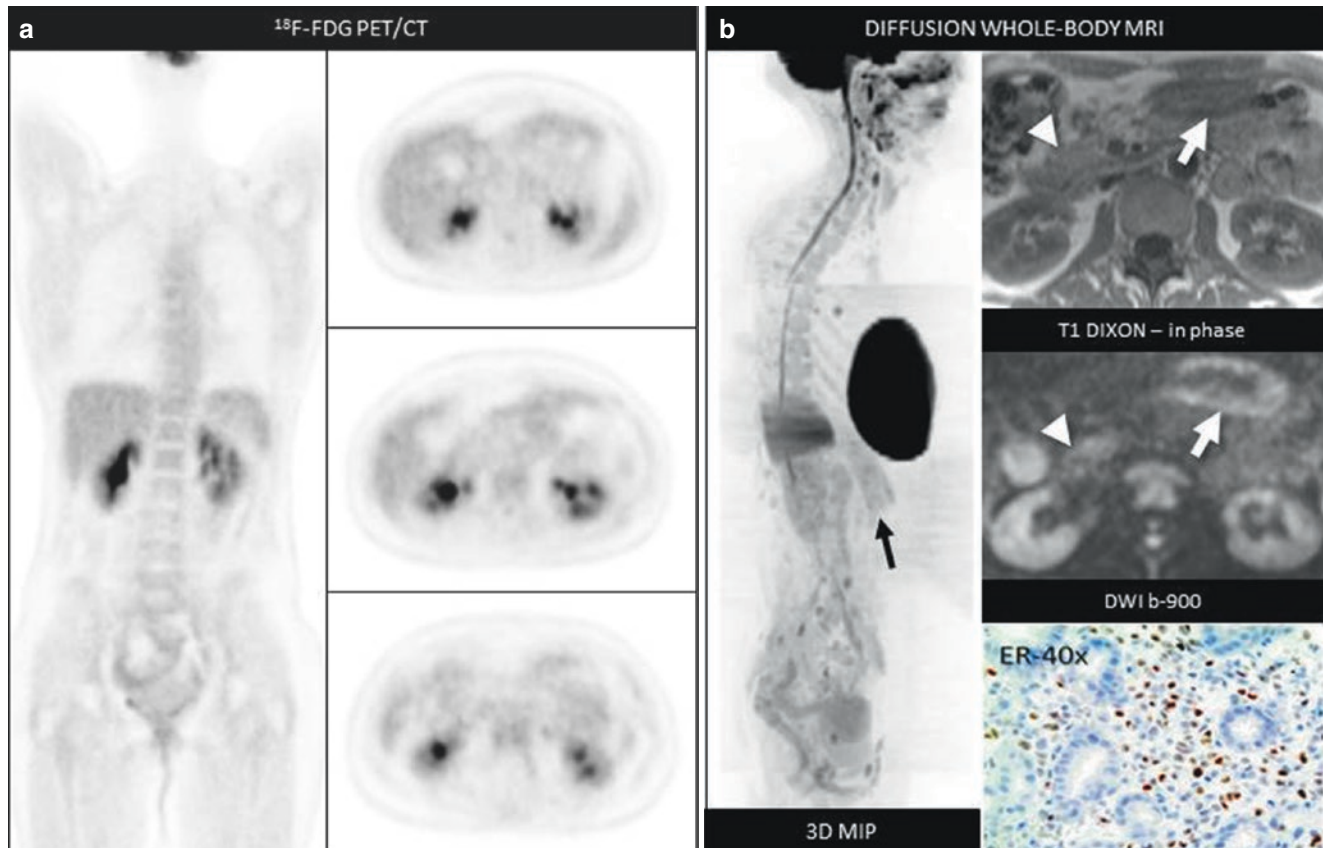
Low sensitivity of ^{18}F -FDG PET/CT for metastases from lobular breast cancer. A 44-year-old woman with operated lobular breast cancer is re-staged with ^{18}F -FDG PET/CT due to suspicion of recurrence after progressive rise in CA 15.3. The FDG/PET examination was negative. After further rises in tumour markers, a second PET/CT (a) is performed 8 months later, confirming the absence of detectable disease. DWB MRI is performed at the same time point (b), with findings suspicious for the presence of abdominal metastases. Suspicious solid tissue on the right anterior renal fascia is visible
